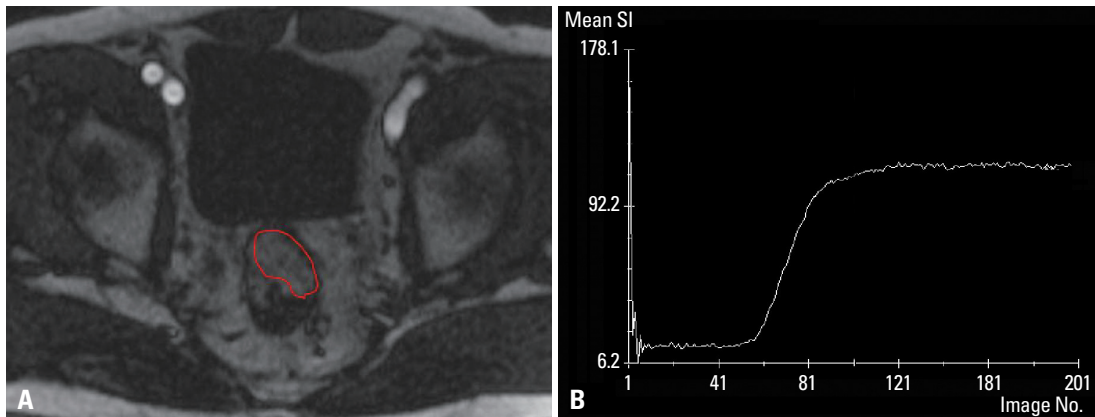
Measurement of DCE-MRI. (A) On DCE-MRI, a ROI was freely drawn within the tumor to encompass the largest area of enhancement. (B) A time-signal intensity curve was generated at a workstation using commercially available software. DCE-MRI, dynamic contrast-enhanced magnetic resonance imaging; ROI, region of interest.
